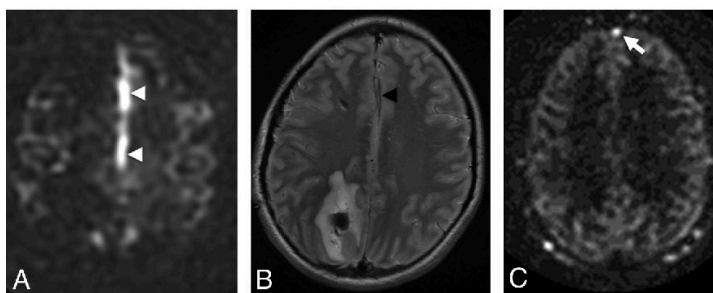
False-positive venous ASL signal in 2 patients. A, ASL signal in the A3 branches of the anterior cerebral arteries (*white arrowheads*) was mistaken for venous ASL signal in a 15-year-old male patient who presented with a right parietal parenchymal hematoma. B, T2-weighted images show localization of this signal to the anterior cerebral arteries (*black arrowhead*). C, ASL signal in the anterior aspect of the superior sagittal sinus in a 70-year-old man with subarachnoid hemorrhage (*white arrow*). This patient had no evidence of a DAVF or shunting on DSA.
